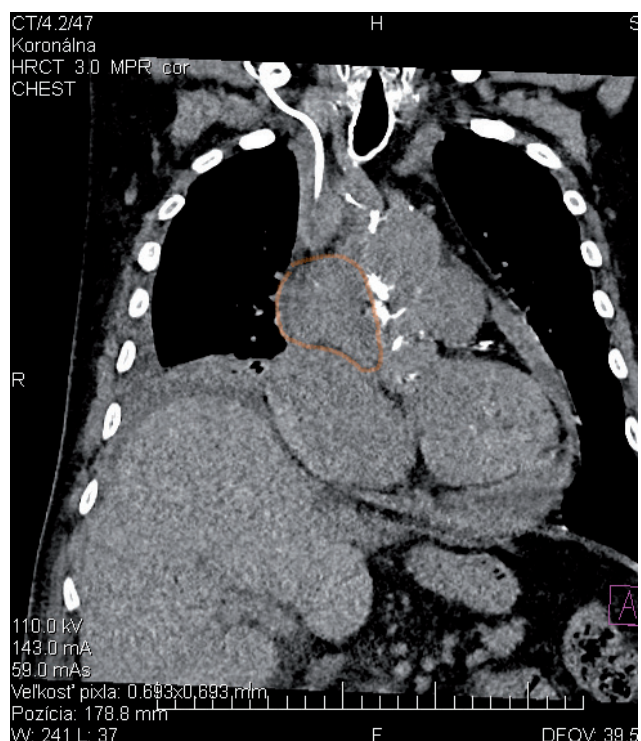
CT scan – suspected pericardial tumorous mass
